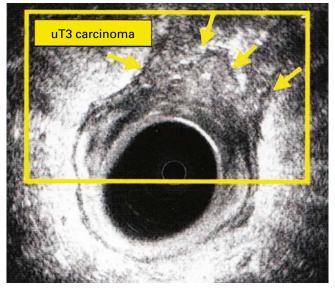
Endosonographic image of rectal carcinoma
